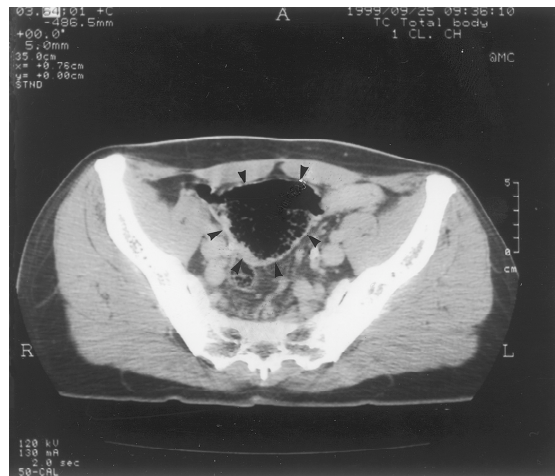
CT-scan: cystic lymphangioma of the mesentery.
